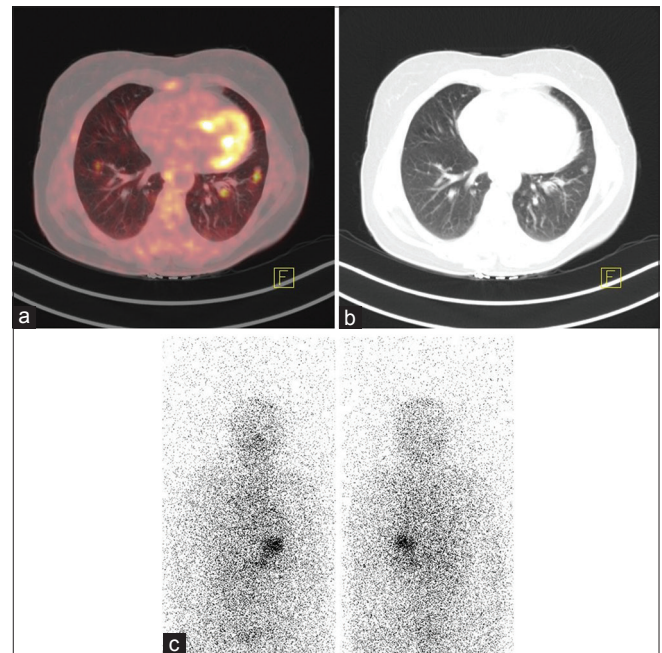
(a and b) Multiple fluorodeoxyglucose avid bilateral lung nodules noted in a 52-year-old female patient with papillary carcinoma of thyroid (Follicular variant) and its corresponding noncontrast computed tomography image. (c) ¹³¹I whole-body scan done in the same patient which shows no abnormal ¹³¹I concentration. Stimulated thyroglobulin of this patient was 654 ng/ml, and CYFRA 21.1 was 2.6 ng/ml
